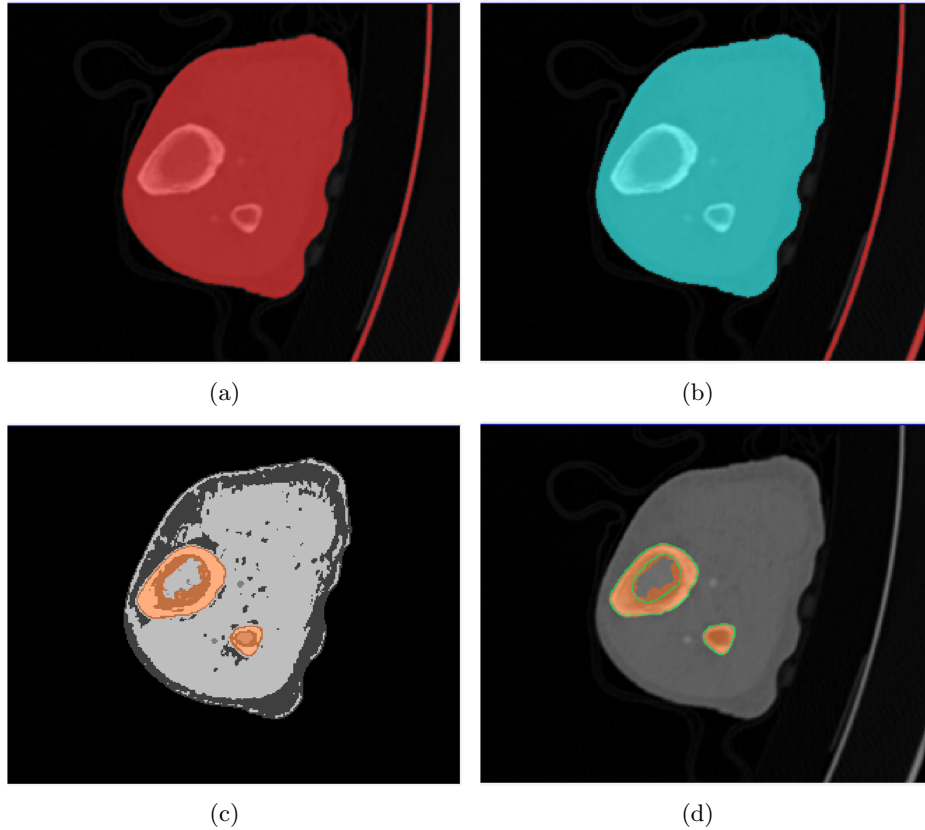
Segmentation protocol of the human tibia: in (a) volume segmentation by global thresholding; in (b) separation of the human body from the CT table by applying a binary RG; in (c) Fuzzy clustering is applied to discriminate the hard and soft tissues in the leg; and (d) segmentation refinement of the inner and outer surface of the bone
